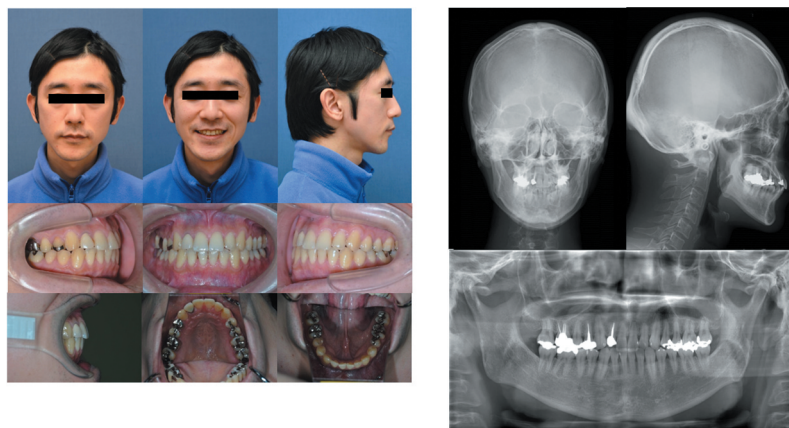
Post-retention photographs and radiographs (age of patient: 36 years 5 months).
